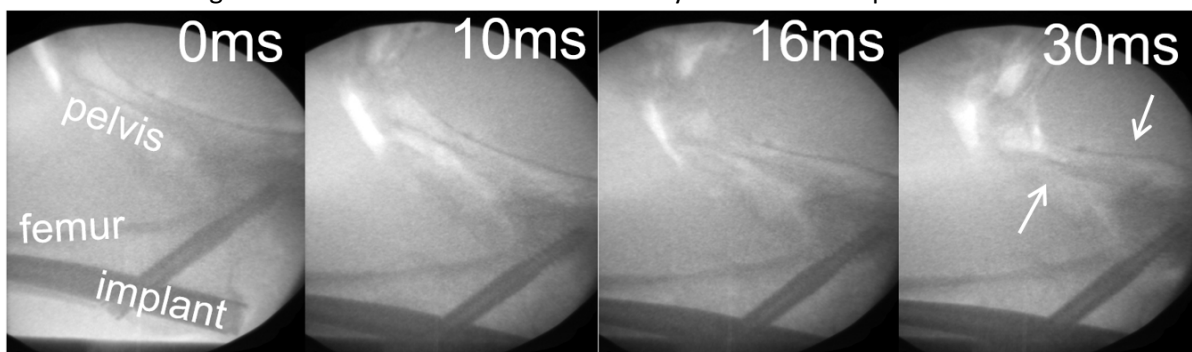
X-ray video frames showing pelvis deformations on the impacting side over 30 ms of the impact. No pelvis deformations are visible at 0 ms, and arrows indicate the discussed deformations at 30 ms.
